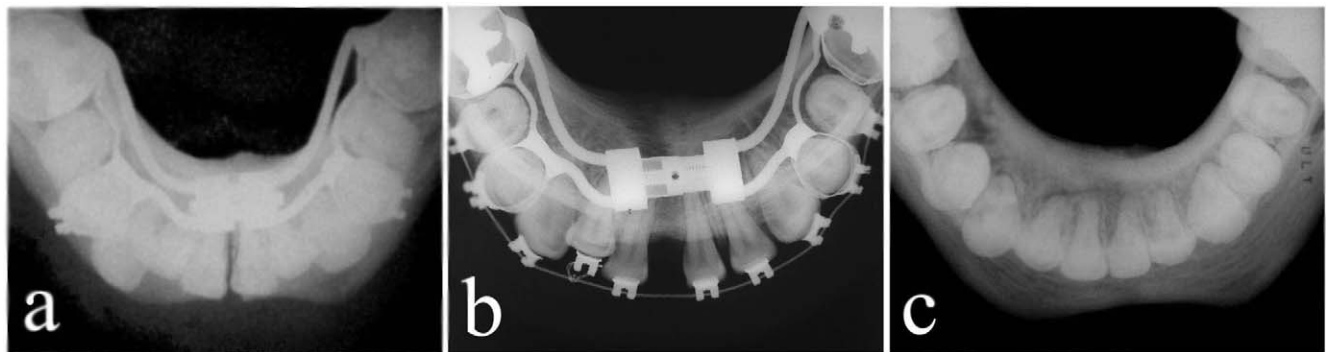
Occlusal radiographs of mandibular anterior region: (a) after surgery; (b) after consolidation period; (c) end of treatment.
